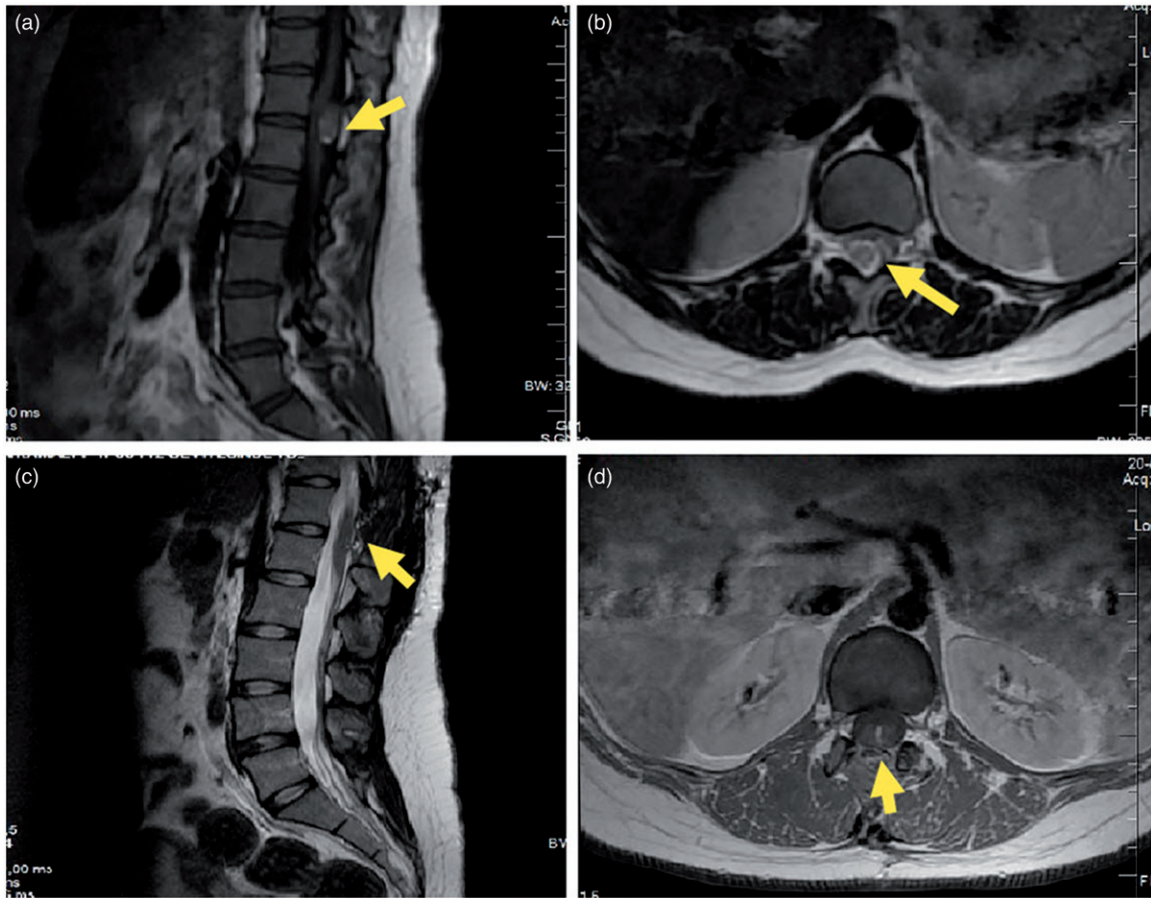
Pre-operative and post-operative lumbar magnetic resonance imaging scans of the lesion. Sagittal t1-weighted MRI partially contrast enhanced mass lesion at thoracolumbar junction (1a). On axial imaging, t2-weighted MRI shows thinned cord and infiltrated part of the lesion on left posterolateral side of the cord (1b). Post-operative MRI scans shows gross total resection of the mass and small contrast enhanced remnant at the operation area (1c,1d).
